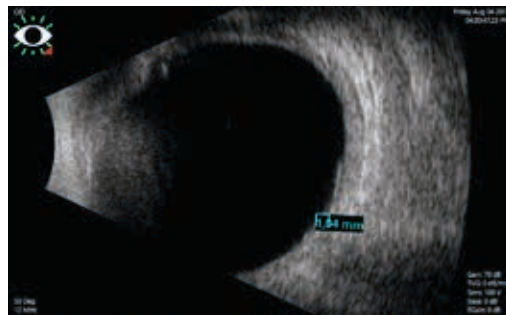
Ultrasonography. It shows the lesion to be about 1,04 mm thickness.
